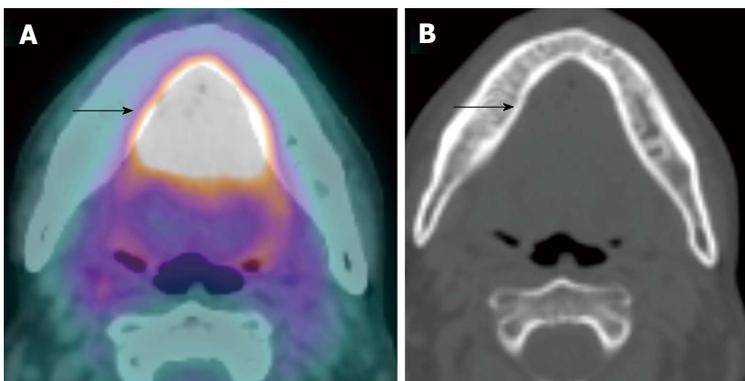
Shine-through artifact on positron emission tomography/computed tomography. A T4a floor of mouth squamous cell carcinoma (arrow) appeared to extend to involve the lingual cortex of the mandible seen on positron emission tomography/computed tomography (CT) (A), which is in fact artifactual. The corresponding CT (B) bone window and intraoperative findings confirmed an intact mandibular cortex.
